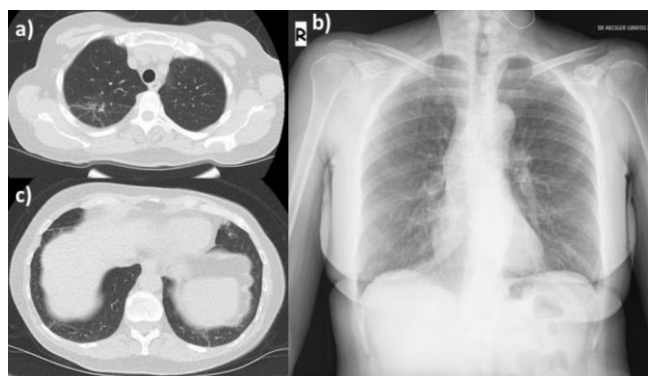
After three months of treatment, thorax CT showed a reduction in the lesions (a) and thorax CT lung section (c), Chest x-ray (b)
